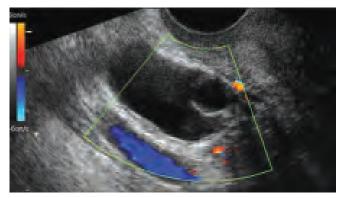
Transvaginal color Doppler imaging of the distally occluded tube following of the injection of the anechoic contrast medium
